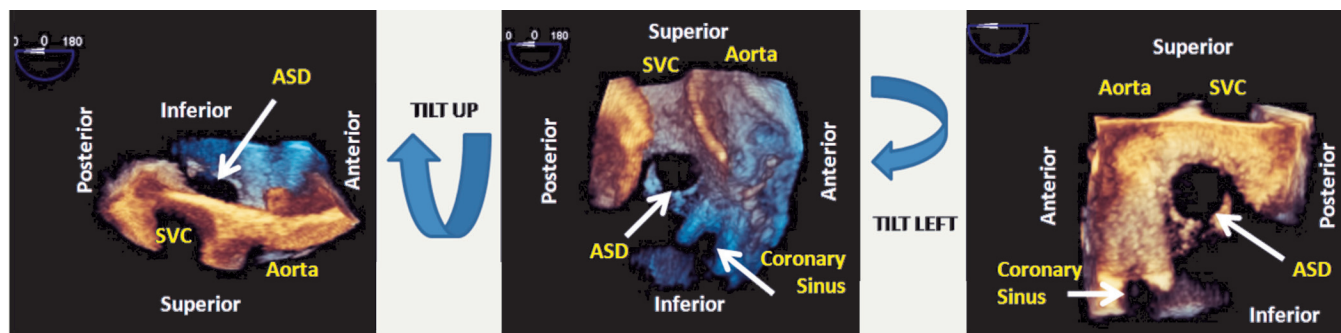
The TUPLE maneuver provides an easy method to image the right and left sides of the interatrial septum. The initial image is a zoomed three-dimensional volume set acquired from a midesophageal zero-degree window. ASD = atrial septal defect. (From Saric M, Perk G, Purgess JR, Kronzon I: Imaging atrial septal defects by real-time three-dimensional transesophageal echocardiography: Step-by-step approach. *J. Am Soc Echocardiogr* 23:1128, 2010.)
